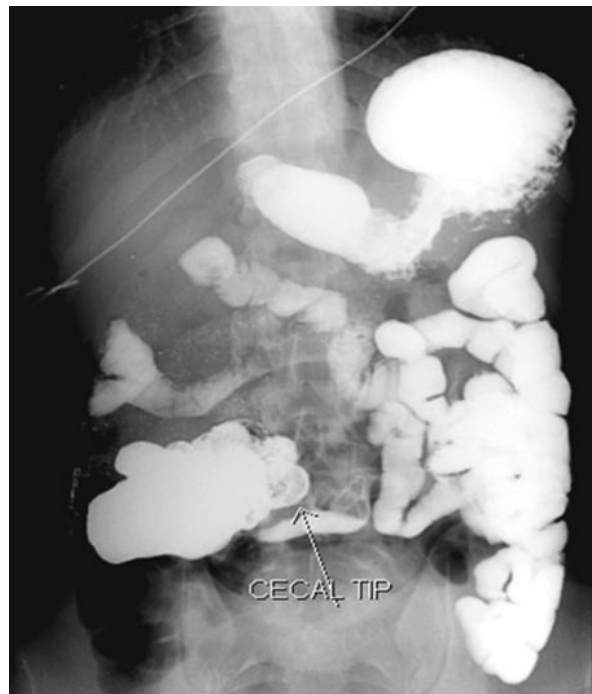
Malrotation in a 10-year-old boy. Delayed radiograph from an upper GI series shows the cecal apex at the level of the L3-L4 intervertebral space. The abnormal location of the cecum suggests a predisposition to volvulus due to foreshortening of the small-bowel mesentery.
